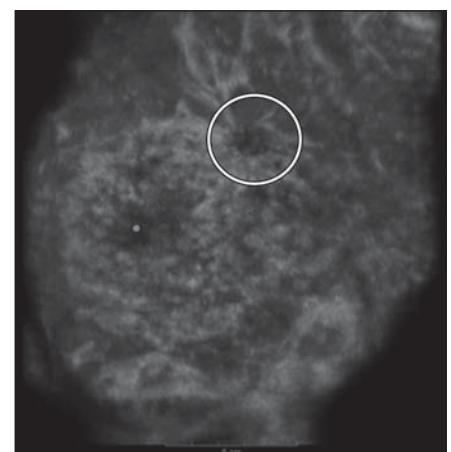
54-year-old woman with mammographically occult cancer seen on automated breast ultrasound. A, Craniocaudal mammographic views show normal BI-RADS density category 3 mammogram. B, Mediolateral oblique views. Circle denotes mole.
